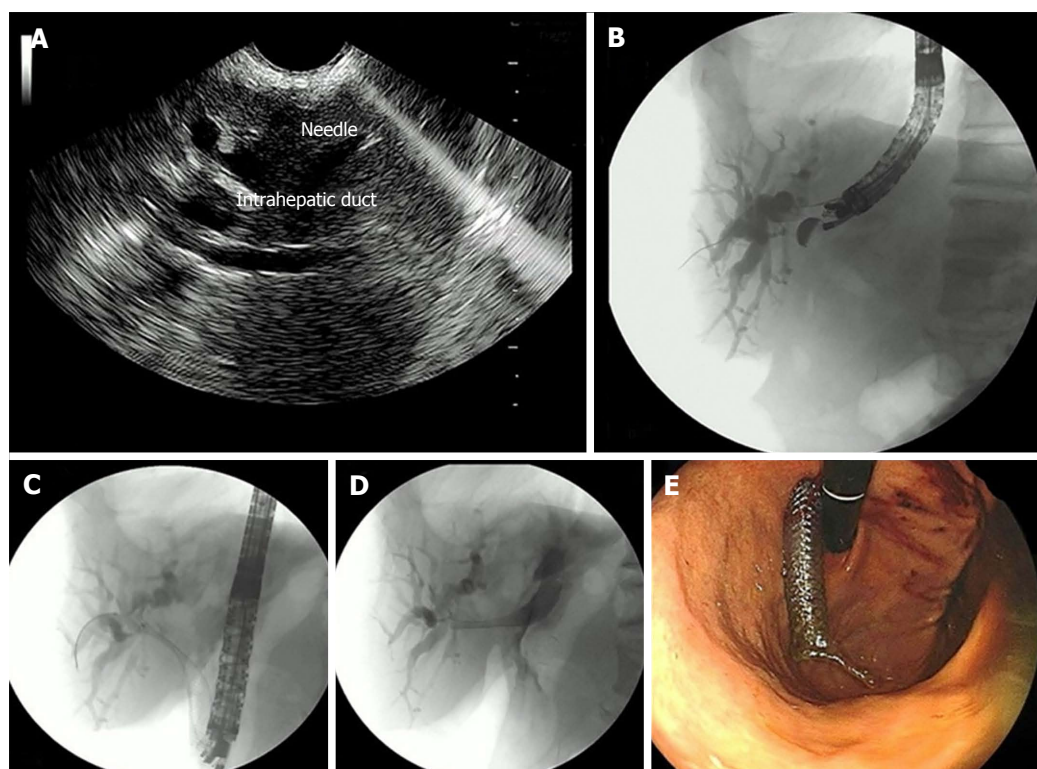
Endosonography-guided hepatogastrostomy. A: Endosonography (EUS) puncture of the dilated biliary intrahepatic duct; B: EUS-guided cholangiography; C and D: Deployment and positioning of the biliary self-expandable metallic stents (SEMS); E: Endoscopic view of the SEMS through the gastric wall.
